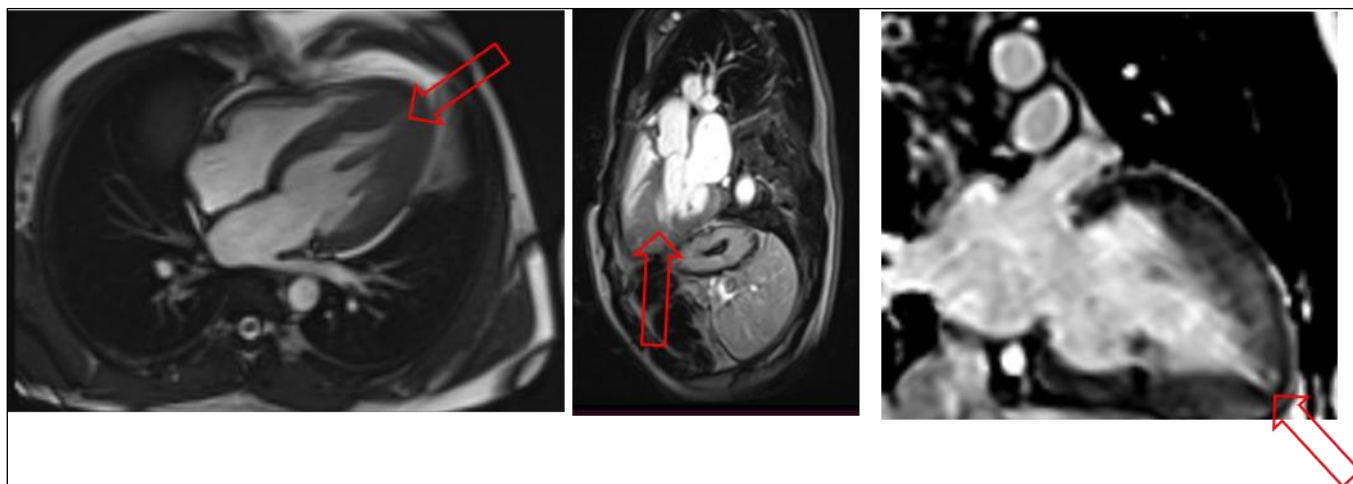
(A) Cardiac MRI, 4-chamber magnitude image (early gadolinium enhancement sequence) demonstrating marked apical myocardial hypertrophy with near-obliteration of the left ventricular apical cavity, producing the characteristic "ace-of-spades" configuration. Basal and mid-ventricular segments are relatively spared. (B) Three-chamber magnitude image confirming disproportionate apical wall thickening relative to the basal septum and LVOT, without evidence of dynamic outflow tract obstruction. (C) image showing patchy mid-wall hyperenhancement localized to the hypertrophied apical segment, consistent with focal myocardial fibrosis a recognized substrate for ventricular arrhythmia in ApHCM.
